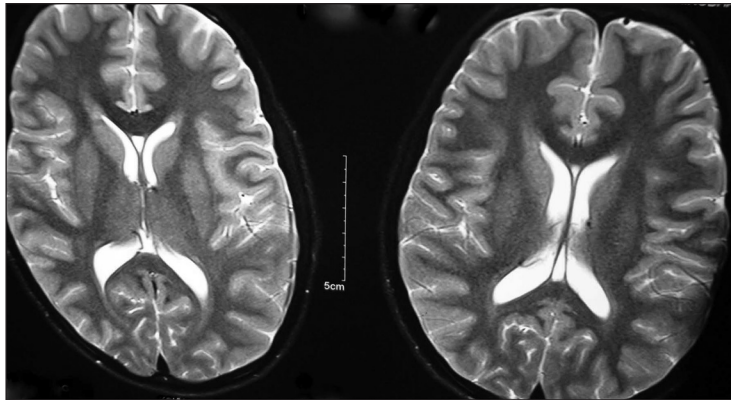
MRI of the brain demonstrated white matter abnormalities
